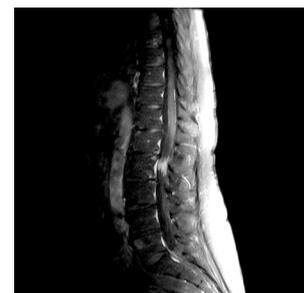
Sagittal T1 post-Gd MRI shows the thickened and highly enhanced roots of cauda equina at L2 level.
